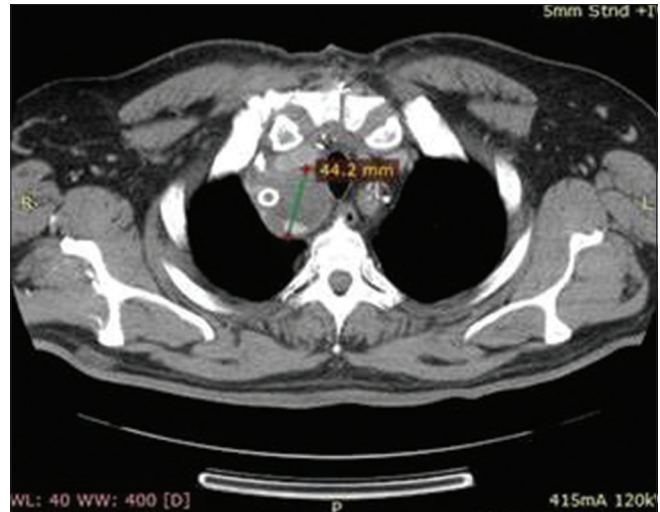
Computed tomography scan images showing previously implanted cover stent due to preexisting aneurysm of innominate artery
